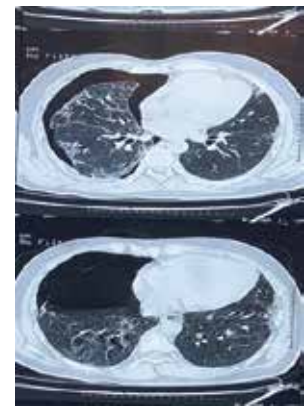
CT chest showing pneumothorax in right hemithorax
